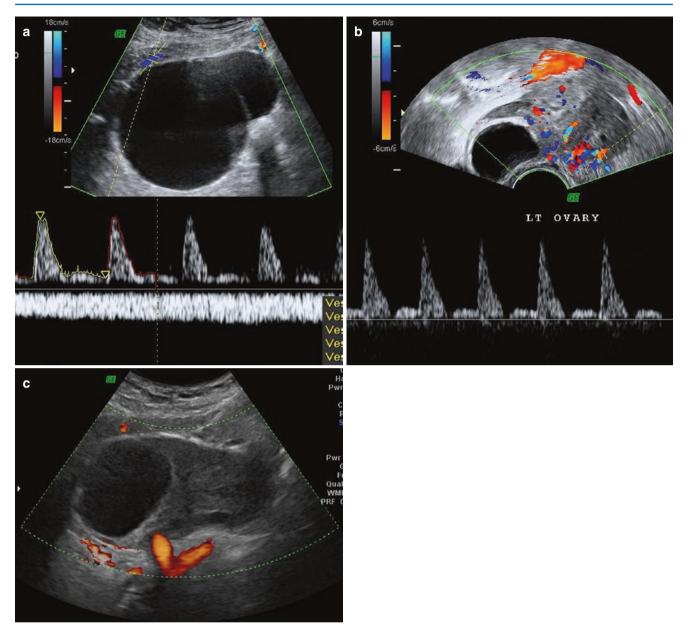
Doppler in torsion. (a) Arterial and venous flow. (b) Only arterial flow. (c) No flow
